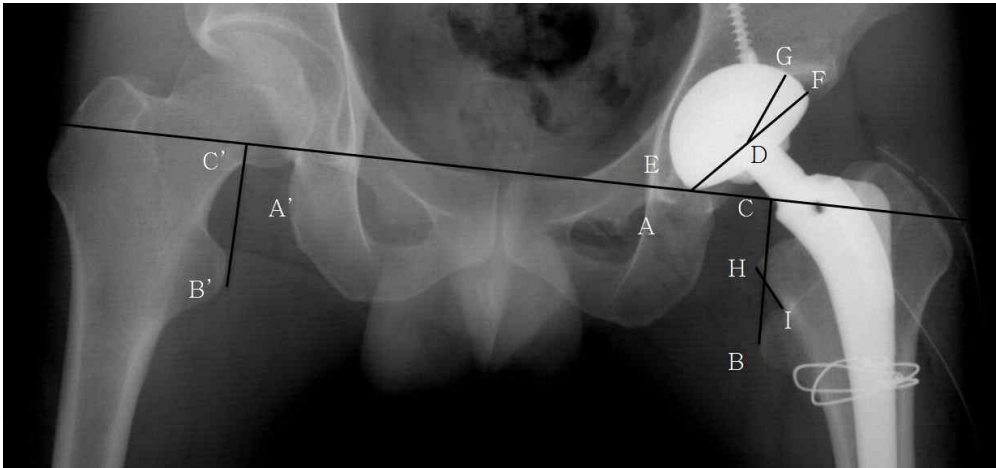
Postoperative radiograph with a patient with Legg-Calve-Perthes disease sequelae. Leg length discrepancy ($\overline{B'C'} - \overline{BC}$) was measured by same method as preoperative method. Cup inclination ($\angle FEC$) was measured by angle between inter-teardrop line ($\overline{AA'}$) and line connecting lateral openings of cup (\overline{EF}). Cup coverage ($\frac{\angle EDF}{\angle EDG} \times 100(\%)$) was measured by percentage of angle of cup in contact with host bone ($\angle EDG$). Neck cutting level (\overline{HI}) was measured by distance from base of lesser trochanter in femoral cortex (I) to osteotomy level in femoral cortex (H).
